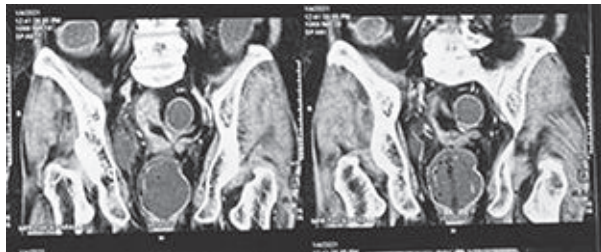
CT scan showing pelvic recurrence in coronal view
